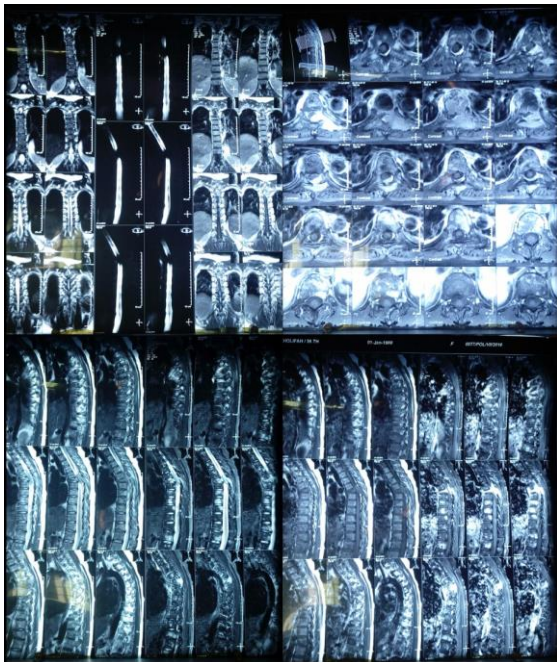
MRI Torakolumbal Ms. SK 36 years old, showed an extradural solid mass involving the T5–T7 spinous process, T5–T7 lamina, T5–T7 inferior articular facies, T5–T7 intra-dural mass, T5–T6 dominant left forus and anterior– media column T6 level; with col-lapse of the T6 vertebrae and changes in the bone marrow of the thoracic vertebrae, probably due to metastases that cause se-vere calcaneal stenosis as high as T5–T6 and spinal cord edema at T5–T7 levels.
